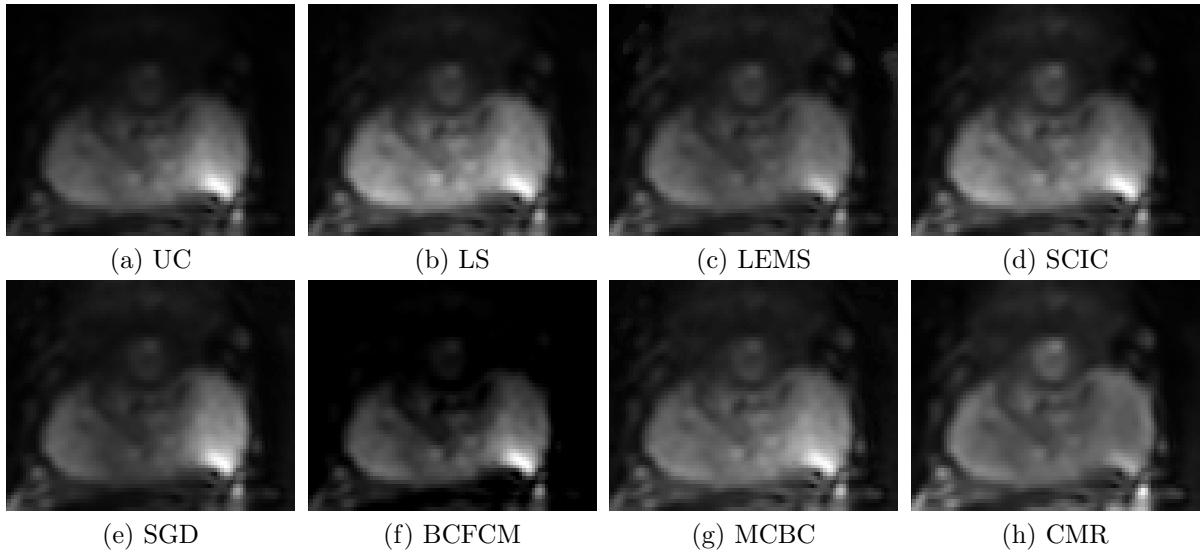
Case 1 with $b=100 \text{ s/mm}^2$. Proposed CMR imaging reduces the bias field and noise in prostate DWI.
